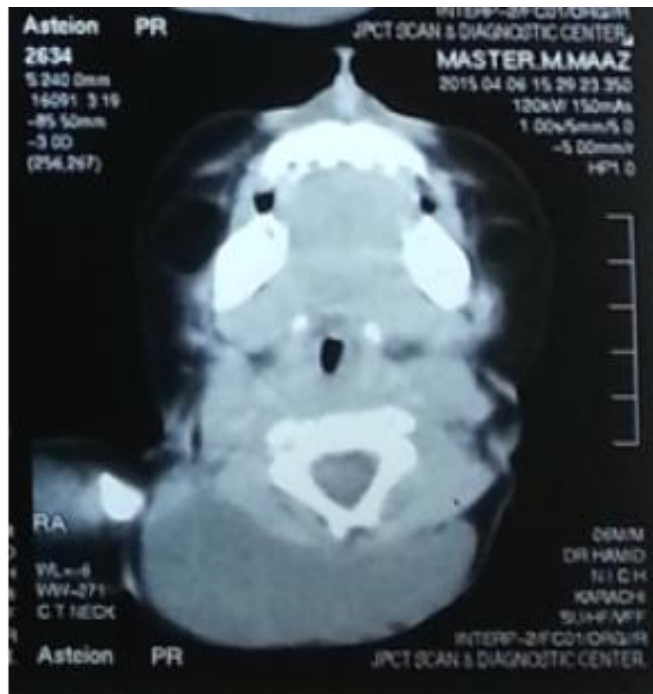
CT Scan shows Cystic Hygiene.
